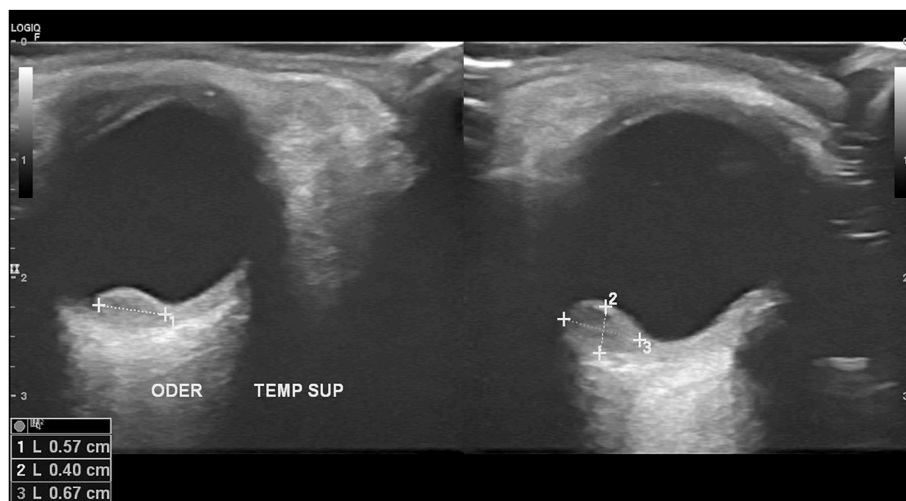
B-ultrasound scan of the right eye at initial examination showing a choroidal dome-shaped protruding lesion with heterogeneous internal reflectivity.
